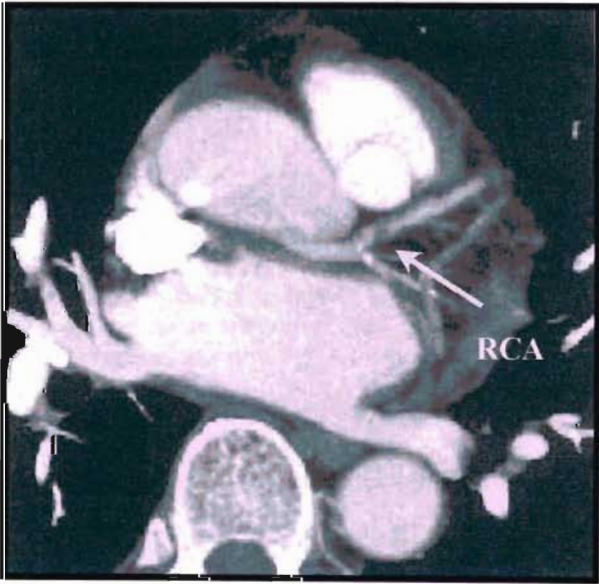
(a): CT image of the proximal coronary arteries
